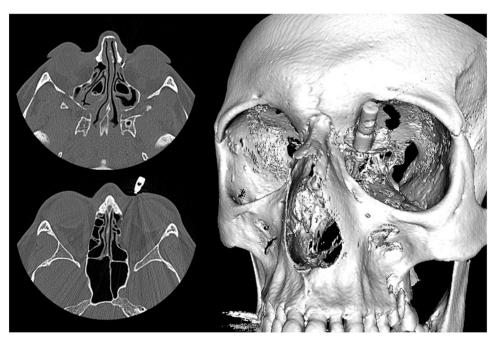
Preoperative computed tomography scans. Top left panel: axial section showing the point of the TASER dart in the left nasolacrimal duct. Bottom left panel: axial section showing the ethmoid (lamina papyracea) bone fracture. Right panel: three-dimensional CT scan reconstruction showing the embedded probe.
